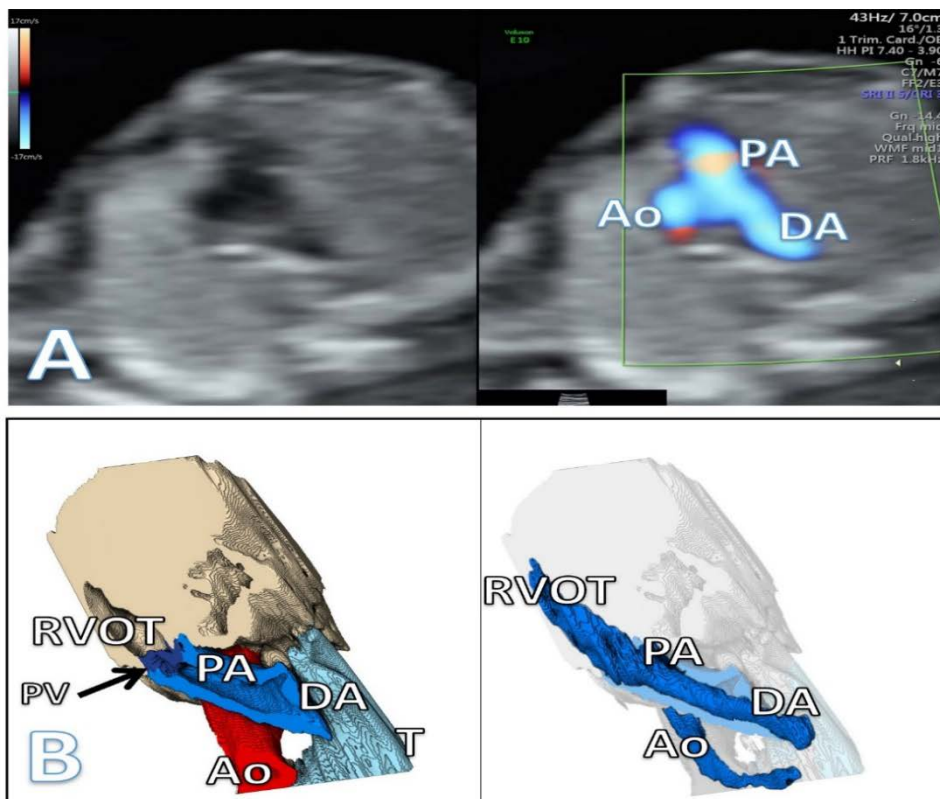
Evaluation of the right ventricular outflow tract. A. Ultrasound duplex mode showing normal right ventricular outflow tract. B. Three-dimensional representation identifying the right ventricular outflow tract and nearby elements (left) and visual representation of the cavities and vessels volume resembling the Doppler examination (right). RVOT: right ventricle outflow tract; PV: pulmonary valve; PA: pulmonary artery; DA: ductus arteriosus; Ao: aorta; T: trachea
